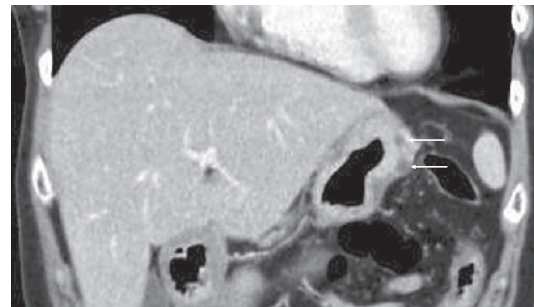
Computed tomography (CT) of the stomach. Oval cyst-like lesions were observed in the gastric wall (arrows) without any extra-gastric lesions.
